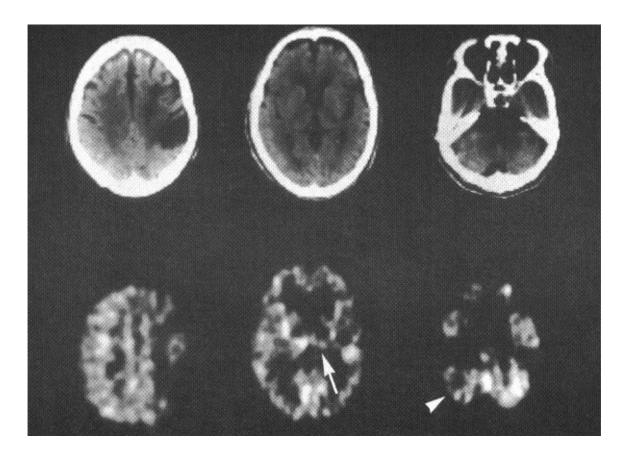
Representative appearances of CT Scan and PET image data at the same brain slices from a 68-year-old man who had suffered from left cortical infarction 5 months previously. Decreases of CMRGlc were observed in the left thalamus (arrow) and in the right cerebellum (arrowhead).
